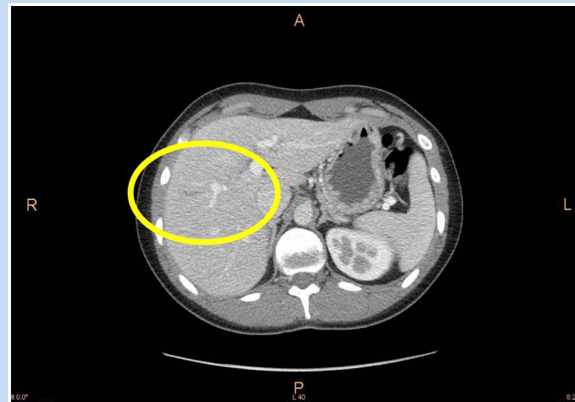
Transverse abdominal/pelvic computed tomography scan at 5 weeks postinjury. Note the absence of the hematoma and laceration in the circled region where the original laceration had occurred, demonstrating significant healing.
